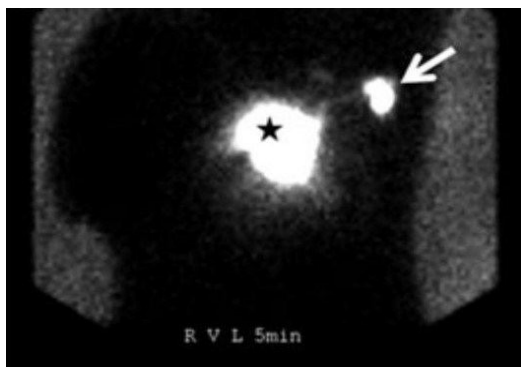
Free hand SPECT of Patient with SLN arrows in the axilla- a preoperative scintigram [15]
